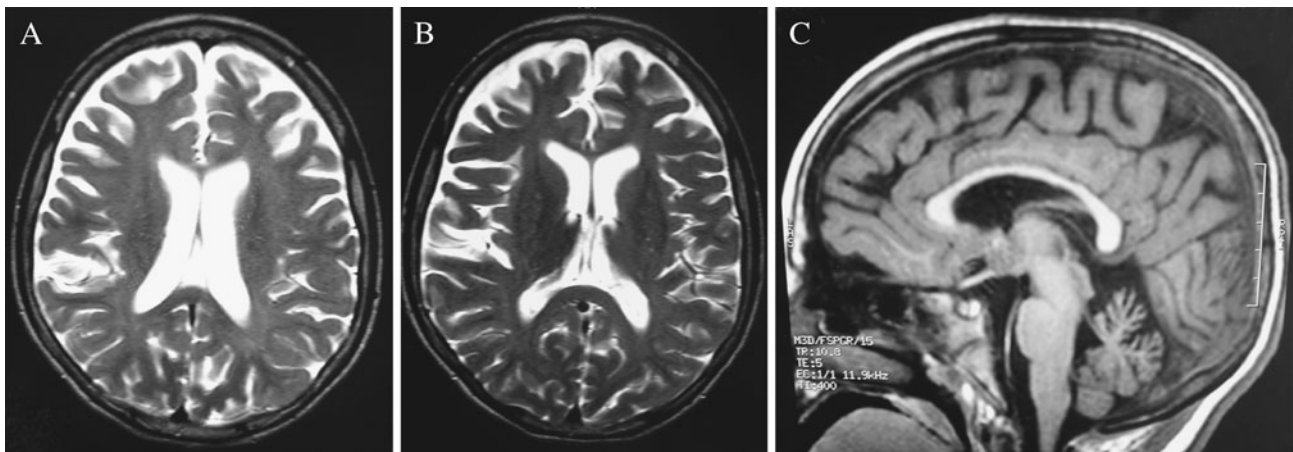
Brain MRI of our patient with NPC disease. (A) and (B) show prominent and diffuse ventricles; (C) shows cerebellar atrophy
